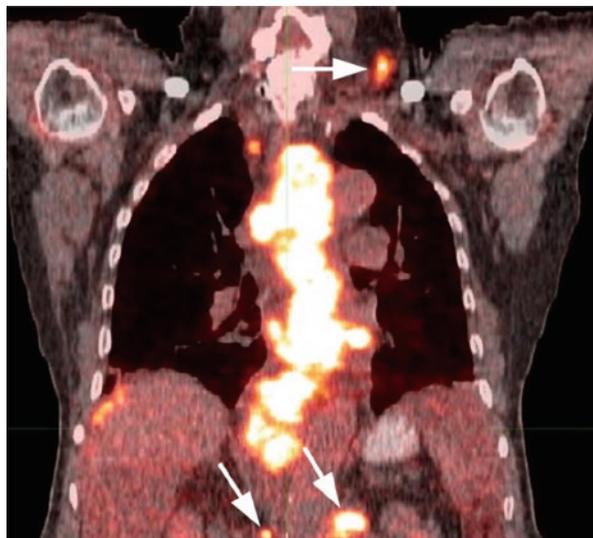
Coronal fused PET/CT image shows hypermetabolic esophageal cancer with multiple periesophageal metastatic adenopathy. There is also left supraclavicular and celiac axis hypermetabolic metastatic lymph nodes (arrows). There is also curvilinear hypermetabolic activity at the right perihepatic region, consistent with subdiaphragmatic metastatic implants
